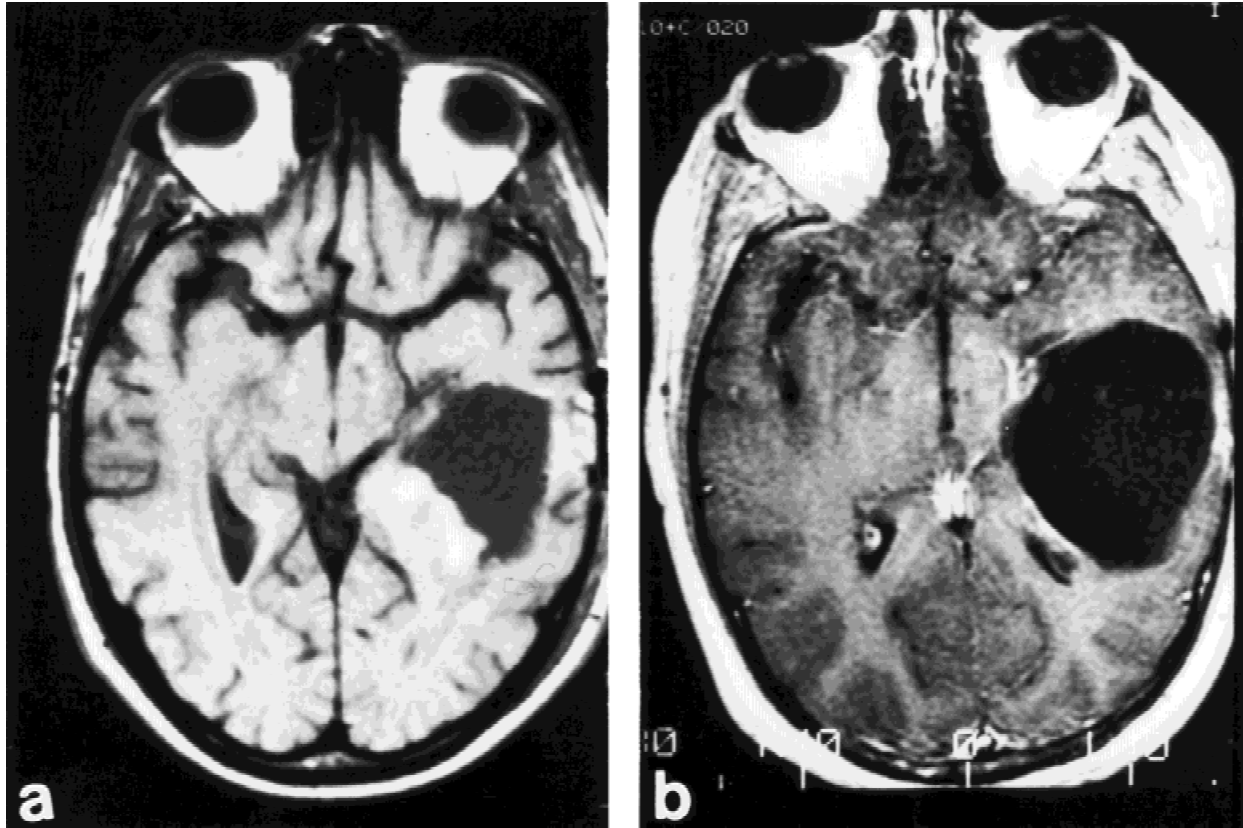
a: Axial T1-weighted MRI with Gd-DTPA contrast of patient 14 in the immediate postoperative period, demonstrating a surgical cavity in the left posterior temporal region with adjacent residual enhancing tumor. Mass effect on the left occipital horn is evident. b: Following three courses of chemotherapy, there has been complete resolution of residual tumor enhancement and decreased mass effect on the left occipital horn.
